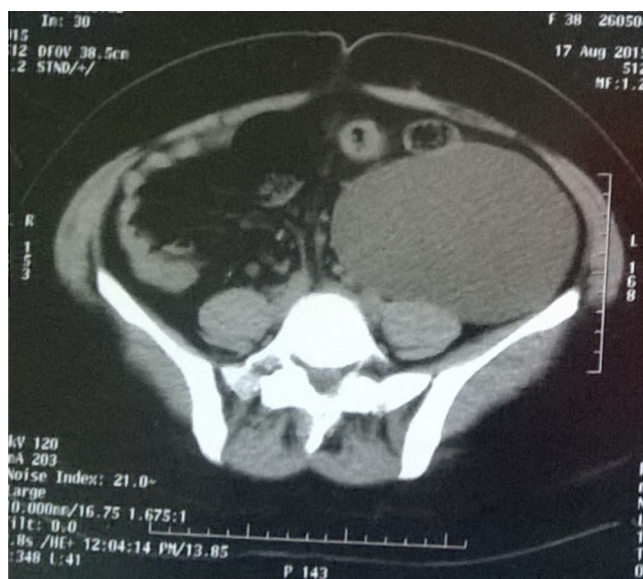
CT showing pelviabdominal cyst on left side.
